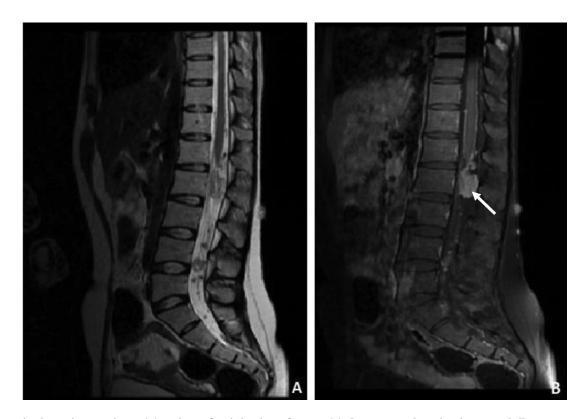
Sagittal MRI images in T2 (A) and T1 after injection of GADO (B) shows an enhancing intra medullary masses suggesting the diagnosis of multiple spinal schwannomas (white arrow).
